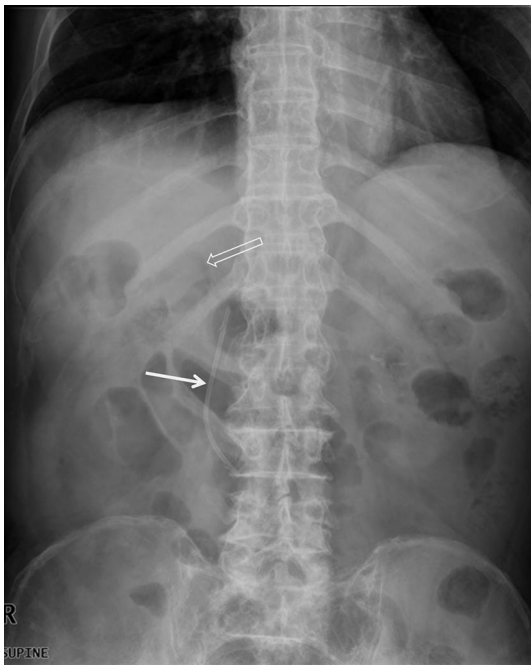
Biliary stent migration in an 87-year-old male with a Klatskin tumor. Abdominal radiograph taken 50 days after plastic biliary stent placement shows distal migration of the stent (*arrow*). Note the air-filled extrahepatic bile duct (*open arrow*)
